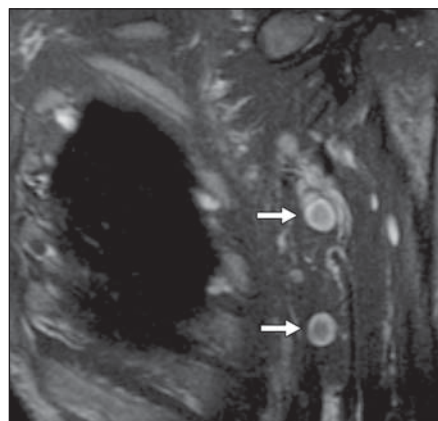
35-year-old man with neurofibromatosis type 1 and shoulder pain. Coronal fat-suppressed T2-weighted MR image of left axilla shows two examples of localized neurofibromas (arrows) consisting of high signal intensity peripherally (myxoid component) and relatively low signal intensity centrally (fibrous component).
